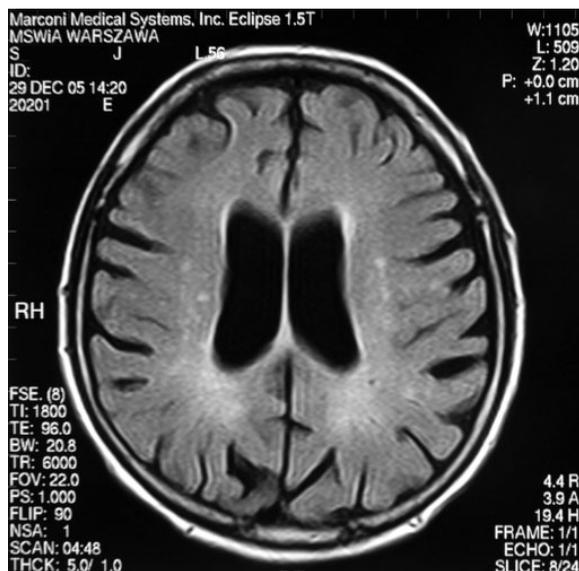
41 year-old woman with 15 year history of SSc and 2 year history of depression and vertigo. MRI, FSE, FLAIR image: moderate atrophy with mild ventricular enlargement and sulci widening, multiple white matter focal lesions and areas of myelin damage with subsequent gliosis.
